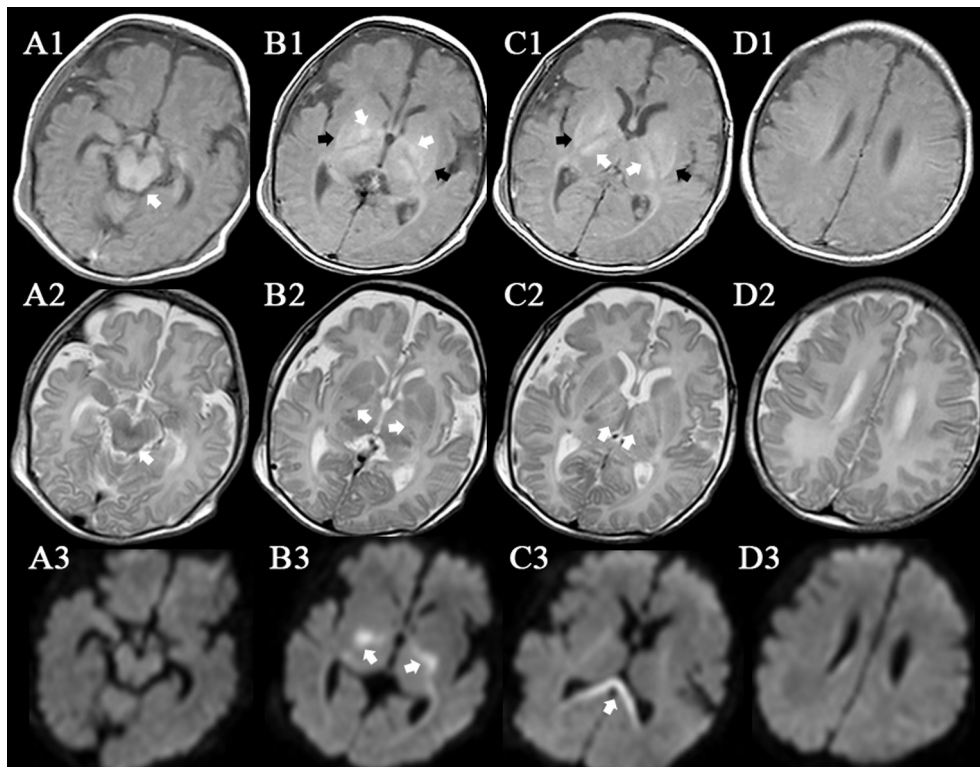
Brain magnetic resonance imaging. T1-weighted images (A1, B1, C1, D1) showed hyperintensity of the dorsal midbrain (A1: white arrow), globus pallidus (B1: white arrow), posterior putamen (B1, C1: black arrow), and lateral thalamus (C1: white arrow). Hyperintensity of the internal capsule was not observed. T2-weighted images (A2, B2, C2, D2) showed hyperintensity of the dorsal midbrain (A2: white arrow), posterior globus pallidus (B2: white arrow), and central part of thalamus (C2: white arrow). Diffusion-weighted images (A3, B3, C3, D3) showed hyperintensity of the globus pallidus (B3: white arrow) and splenium of the corpus callosum (C3: white arrow). White matter injury was not present. Cortical highlighting was not observed.
